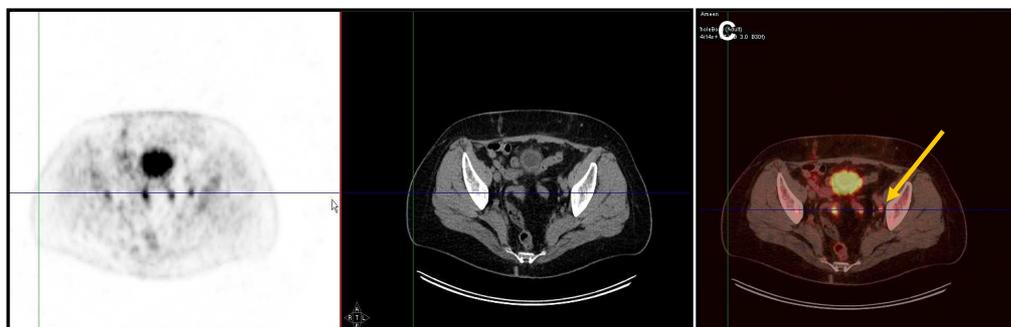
(A)The FDG-PET image showed three focal areas of uptake in the pelvis. (B) CT image and fusion images (C), the left arrow is pointing to the pathological FDG uptake in the left iliac lymph node while the right arrows showed that the other two FDG focal areas are due to physiological intestinal uptake.
